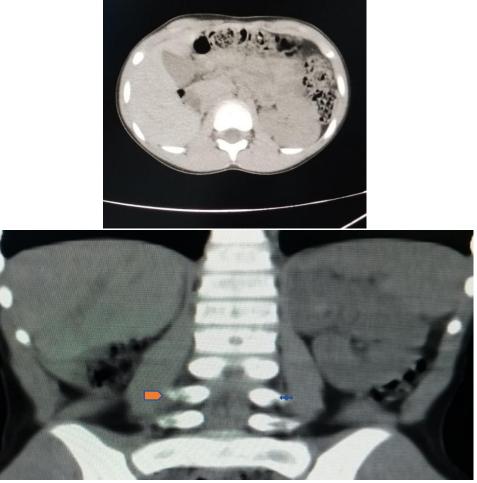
and 1b are axial and coronal reformatted non contrast enhanced computed tomography images showing empty right renal bed (orange arrow head) and the left kidney(blue asteris).
